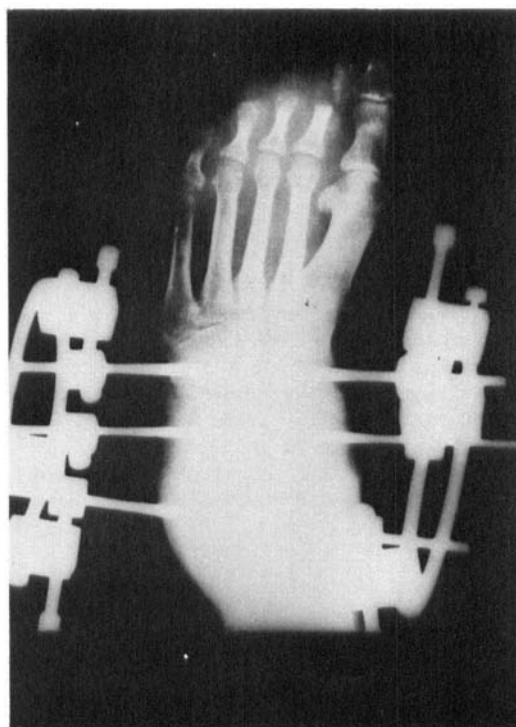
Postoperative X-ray showing the centripetal compression device applied to the foot.
